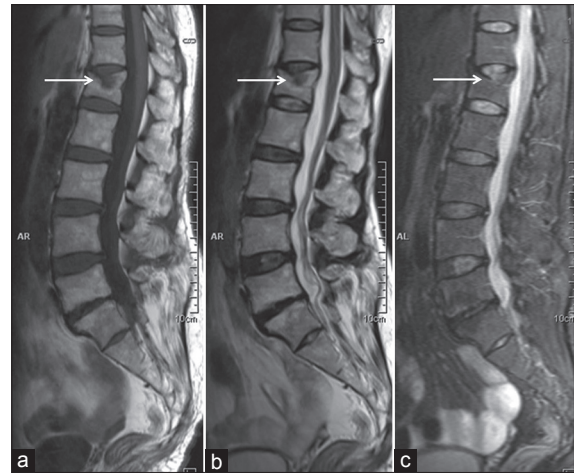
Sagittal T1 W (a), T2 W (b) and STIR (c) MR images of spine show moderate/grade 2 fracture in D12 (arrow) without any edema suggestive of chronic fracture
